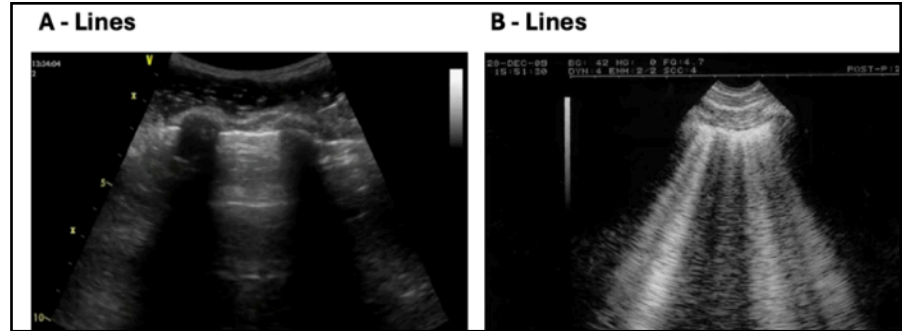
Lung ultrasound demonstrating A-lines in normal lung and B-lines representing pulmonary interstitial edema.
